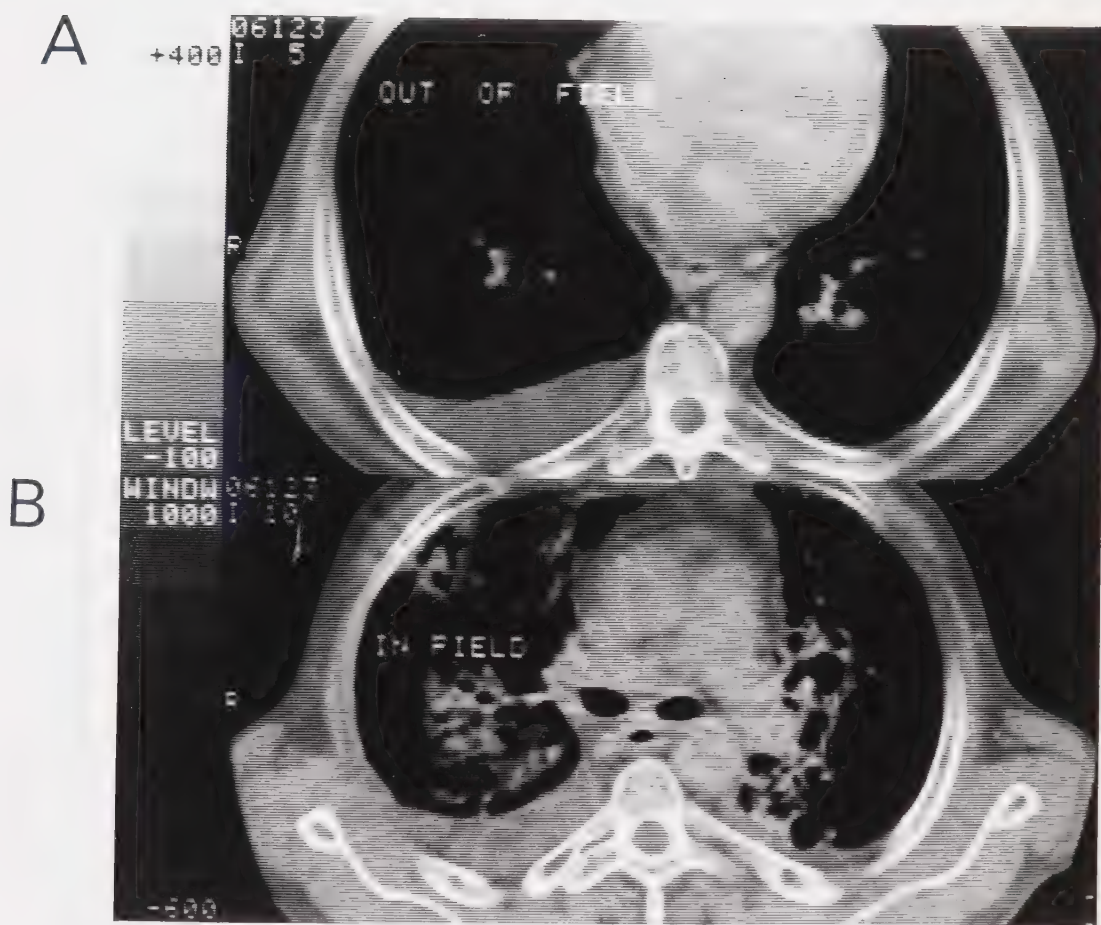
CT scan of human lung (A) normal lung
